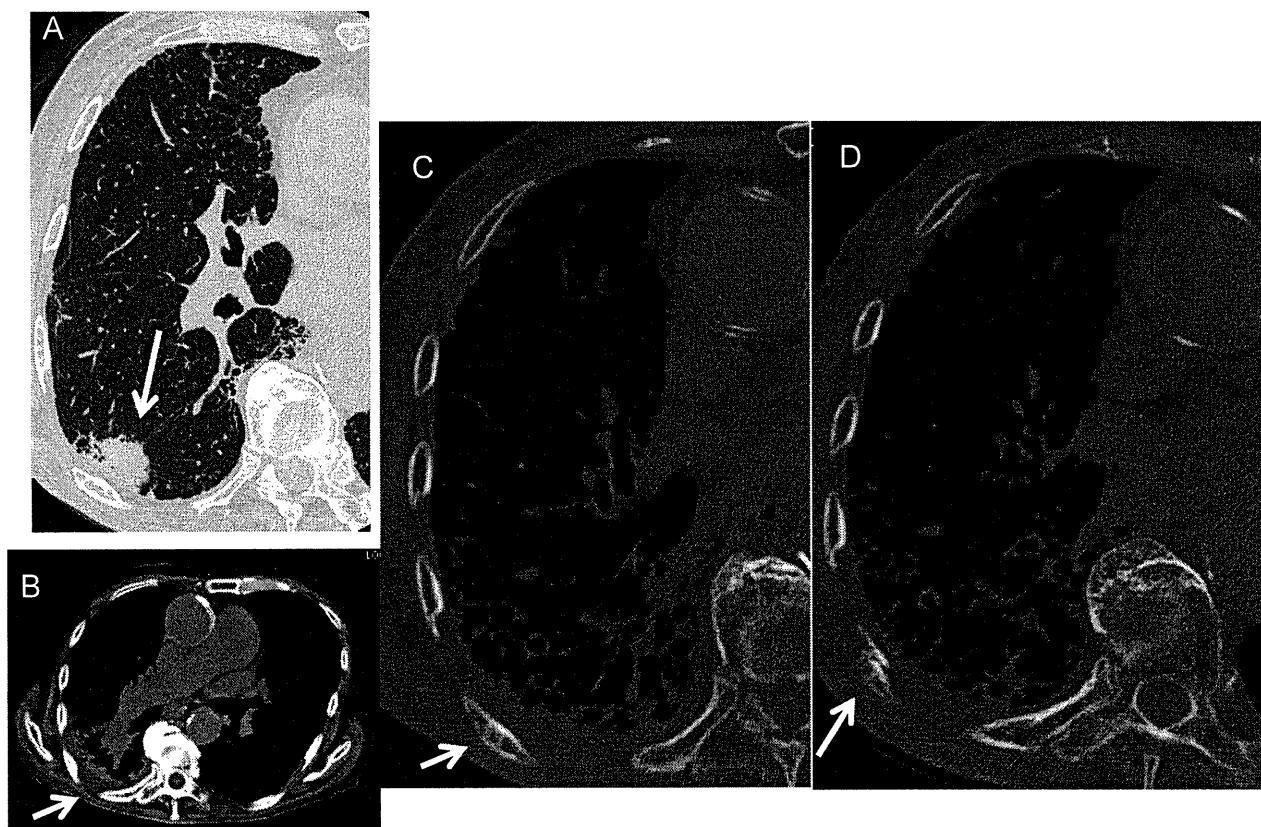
An 85-year-old man with a rib fracture after SRT. A, A preradiotherapeutic thin-section CT showing a spiculated nodule with air-containing spaces (arrow). B, Seven months later after SRT, CT shows edema of the right chest wall adjacent to the tumor, as evidenced by asymmetrical swelling and effacement of the fat planes (arrow). C, On follow-up CT at 13 months after SRT, thin-section CT with a bone window setting demonstrates thinning of cortex with mild sclerotic foci of the medulla in a rib. D, At 20 months after SRT, rib fracture with malalignment of the cortex is apparent (arrow).
